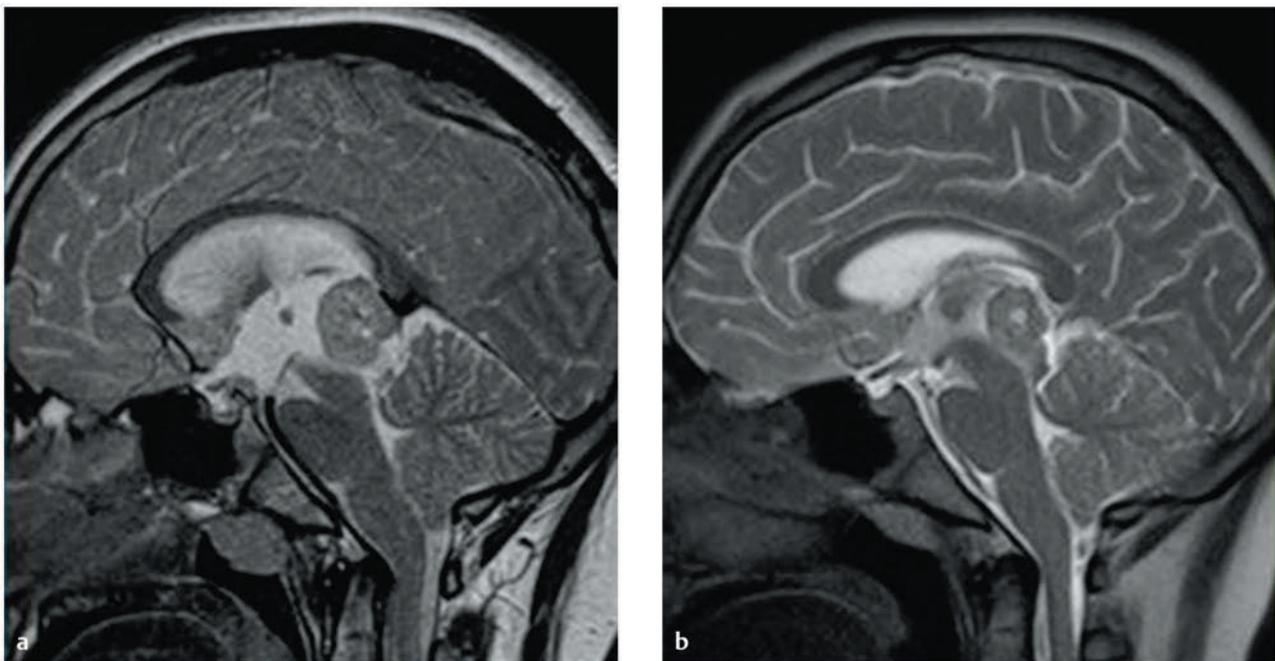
(a) T2-weighted sagittal magnetic resonance image showing hydrocephalus secondary to pineal germinoma. (b) Following 3 days of treatment with dexamethasone, the tumor and hydrocephalus decreased in size.
